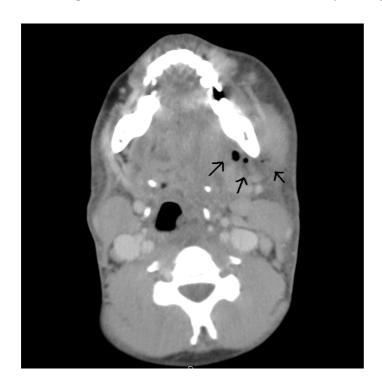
CT scan demonstrating airway deviation and neck collection. Arrows outlining collection with marked inflammatory changes
